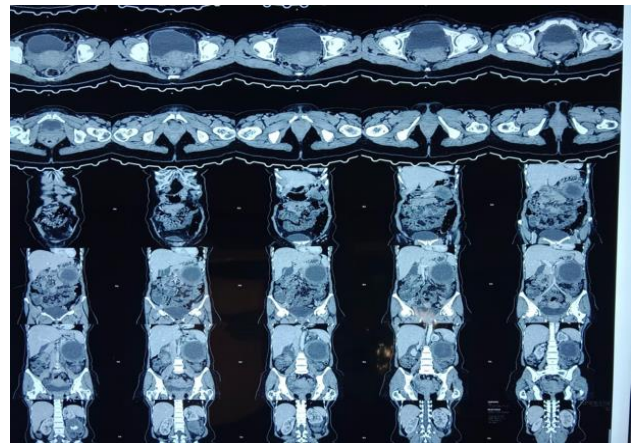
Preoperative CT scan image of cyst.
